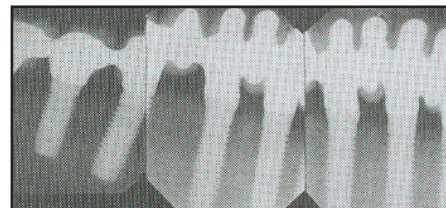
The first year loading periapical radiographs showed an average of 0.07mm bone loss from final prosthesis delivery. After the first year of loading, a slight bone gain was observed, but the vast majority demonstrated 0mm of bone loss.
